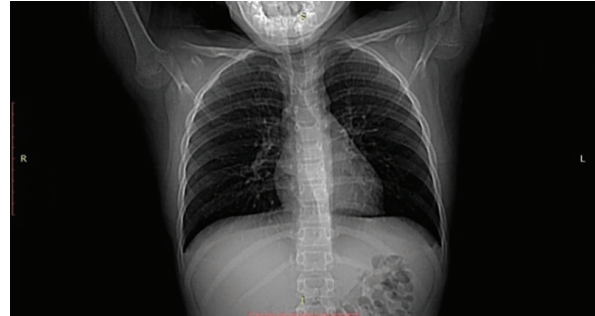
A chest CT revealed a hazy ground glass opacity along the minor fissure in the lateral segment of the right middle lobe.
